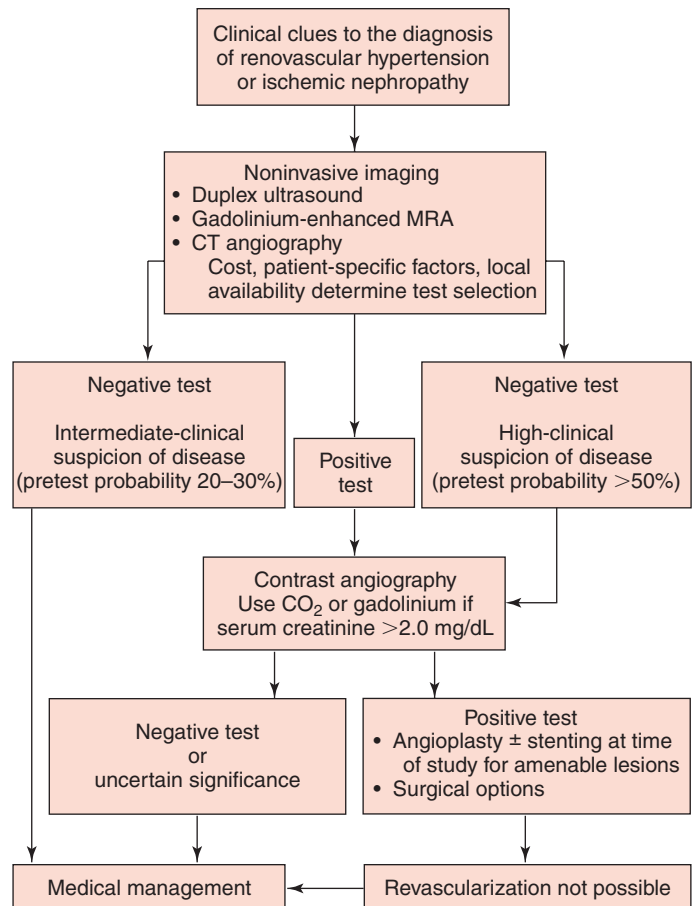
Diagnostic approach for renovascular hypertension. CT, computed tomography; MRA, magnetic resonance angiography.
